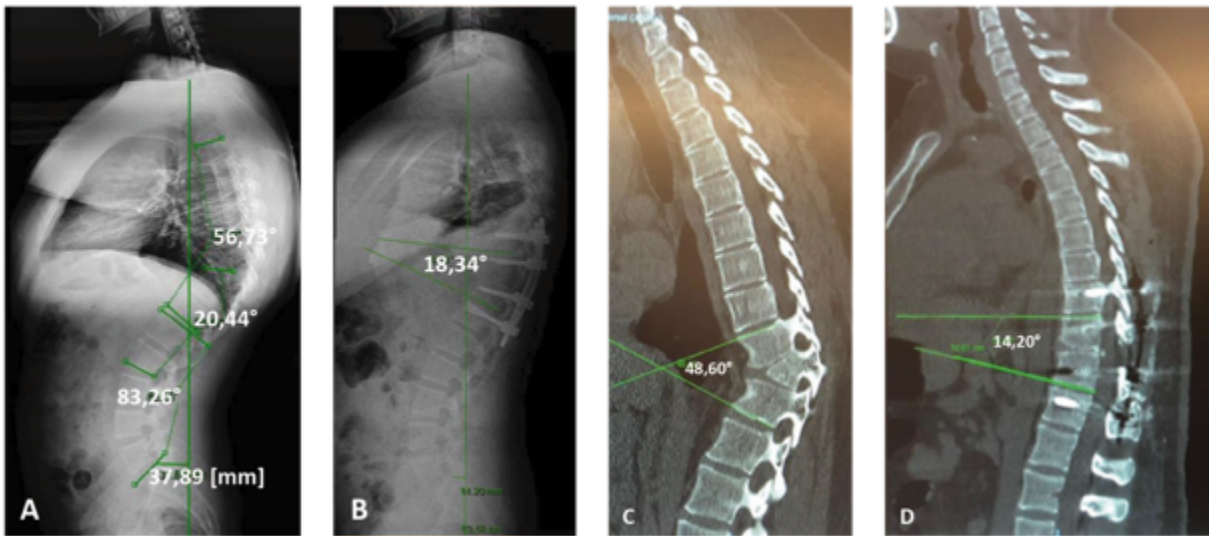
Pre and Postoperative X-rays show a significant thoracic deformity improvement (A and B). Pre and Postoperative CT scan show a T9T11 kyphotic correction from 48° to 14° (C and D).
